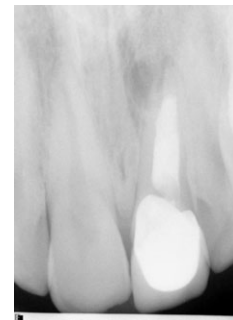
Periapical X-ray tooth no. 21 is hopeless.
